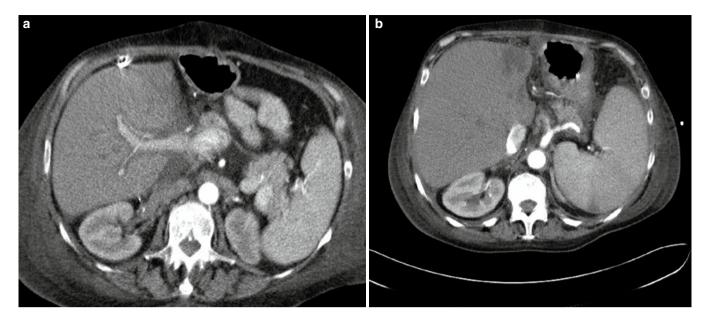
(a) Arterial phase contrast enhanced CT scan of a right lobe split-liver graft demonstrating normal arterial and portal vein perfusion. (b) A further arterial phase contrast-enhanced scan of the same graft demonstrating proximal occlusion of the hepatic artery and an area of necrosis at the anterior right margin. The patient required re-transplantation.
